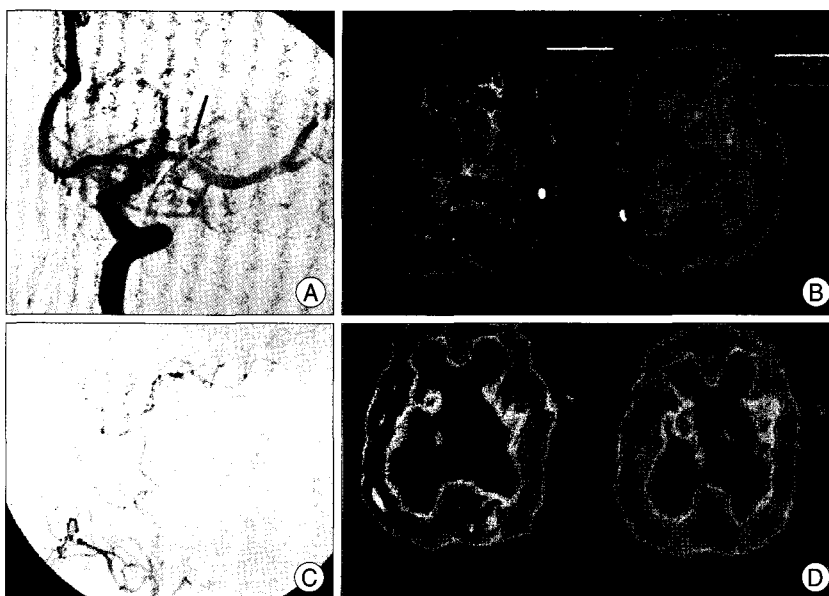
A 45-year-old man presented with presenting crescendo TIA (right hemiparesis and motor aphasia) A : ICA angiogram demonstrates left M1 stenosis (arrow). B : Preop. SPECT demonstrates a loss of vascular reserve capacity on left MCA territories. C : Postoperative. external carotid angiogram showing excellent filling of Left MCA territory by the widely patent STA bypass D : Postoperative. SPECT demonstrating normal blood flow without steal phenomenon.
